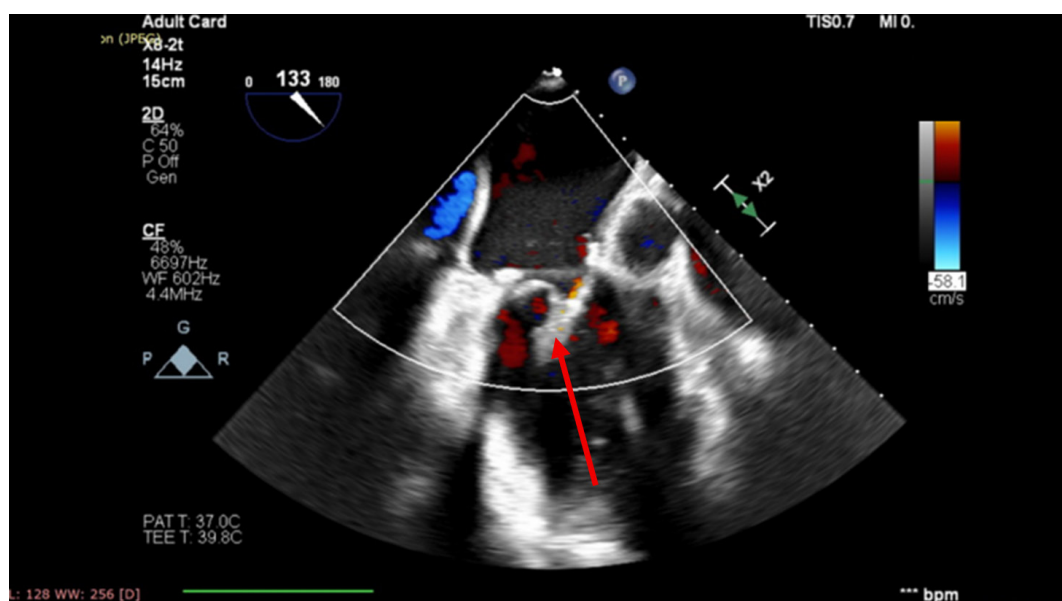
Post-repair transesophageal echocardiographic control demonstrating absence of residual mitral regurgitation and a broad leaflet coaptation (red arrow) zone of approximately 15 millimeters.
